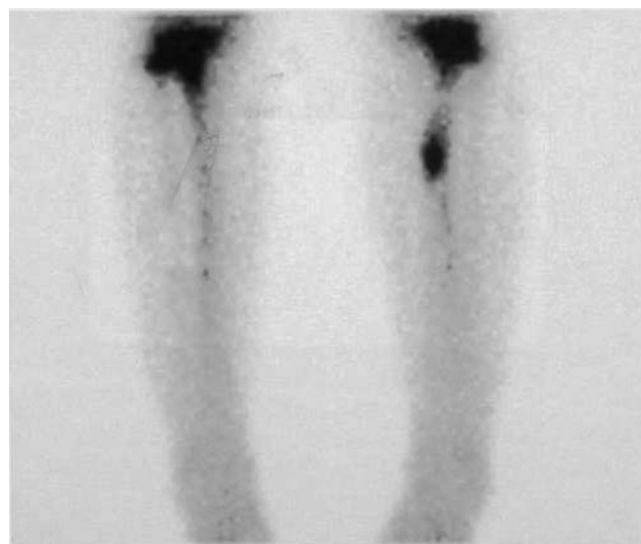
Bilateral bone scan demonstrating normal scintigraphy (*left*) versus the focal uptake pattern of a typical tibial stress fracture (*right*).
